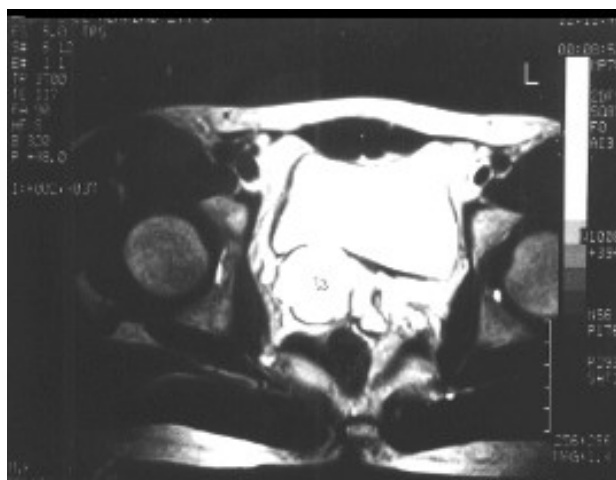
MRI (axial T₂-weighted image), right seminal vesicle cyst, shows the same signal as urinary bladder (Case 2).
